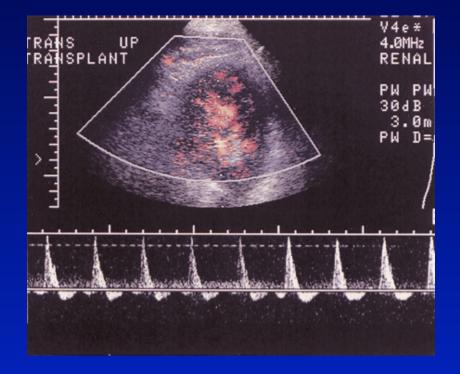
Severe transplant rejection. (a) Duplex color Doppler US image shows a spectral waveform in which the arterial flow in diastole is reversed. Differential diagnosis for this finding includes acute tubular necrosis and renal vein thrombosis. (b) On another duplex image, the spectral waveform shows that the renal vein is patent, thus the diagnosis of renal vein thrombosis is excluded. Findings from biopsy confirmed transplant rejection.
